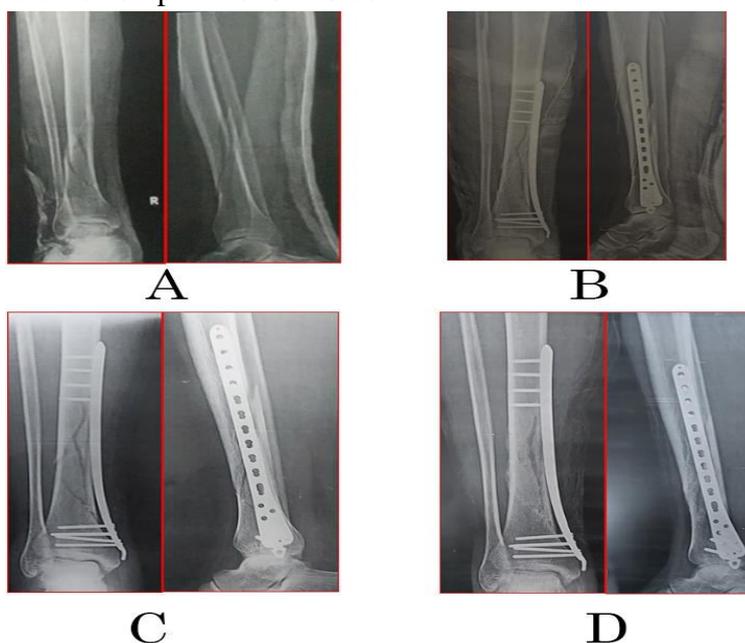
A case of male patient (57 years), diabetic and cardiac, RTA, closed right fracture of lower third tibia 43A1 was fixed by MIPO, with fracture of fibula Webber C not fixed. A: pre operative x-ray AP and lateral. B: Post operative x-ray AP and lateral. C: follow up after 2 months AP and lateral. D: follow up after 6 months AP and lateral. After 6 months Olerud and Molander score was excellent and no complications was documented.
